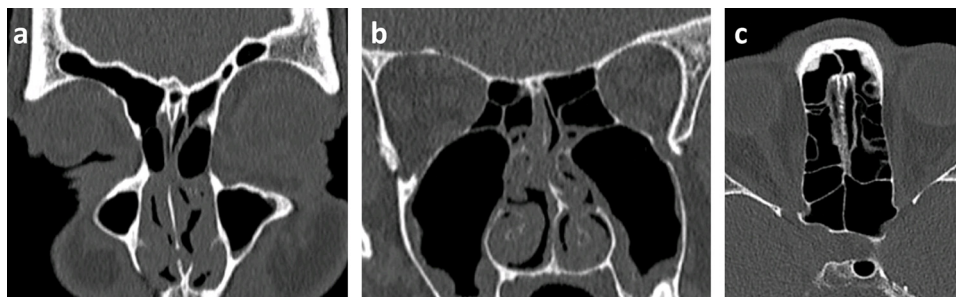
CT features of chronic respiratory rhinitis in case 1. a: Anterior coronal section through the frontal and maxillary sinuses showing them to be intact and the integrity of the olfactory nose (anterior ethmoid) in contrast with opacification of the respiratory nose due to diffuse mucosal hypertrophy. b: Posterior coronal section showing marked hypertrophy of the mucosa of the inferior turbinates, which appears to extend to the mucosa of the free edge of the turbinates and the middle meati; the posterior ethmoid (olfactory nose) has a healthy appearance; slight opacity lining the floor of the maxillary sinus. c: Axial section showing the integrity of the ethmoid (olfactory nose) and sphenoid sinuses.
